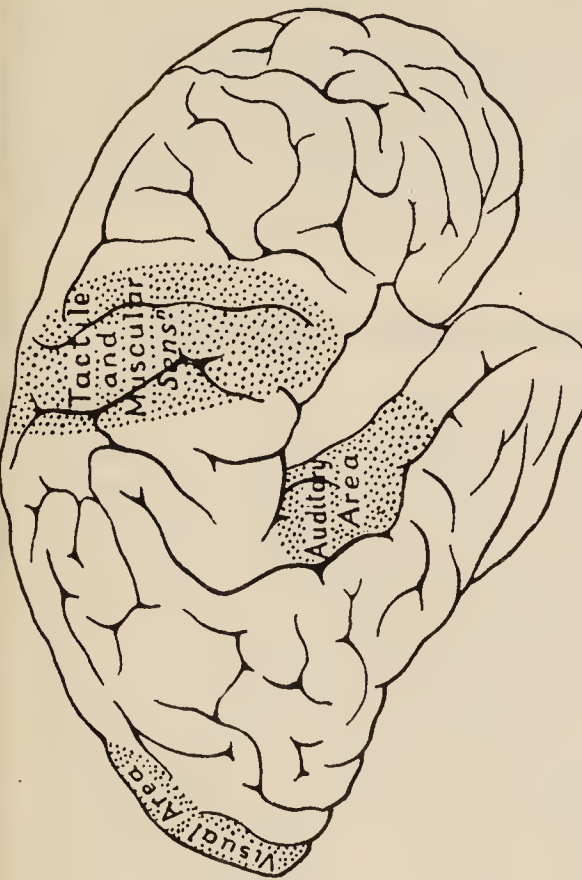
SENSORY AREAS ON THE OUTER ASPECT OF THE CEREBRUM (FLECHSIG).
